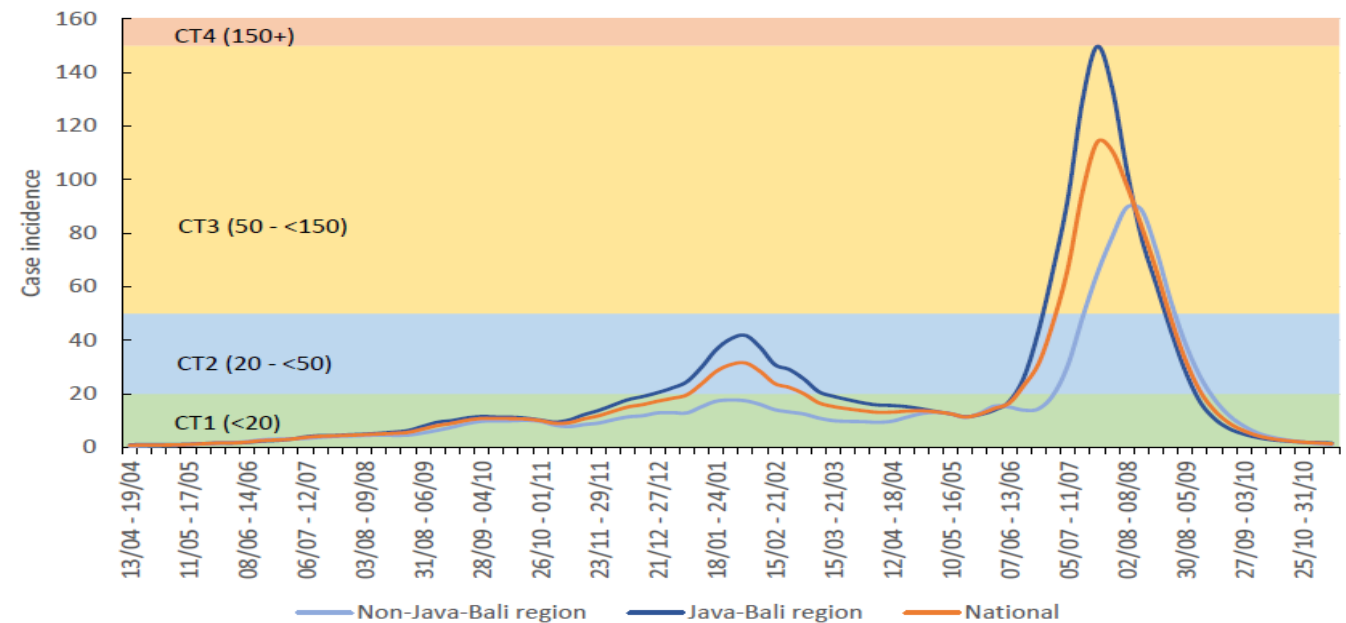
Incidence of COVID-19 per 100 000 population per week averaged over a two-week period reported at national and subnational levels (Java-Bali and non-Java-Bali) from 13 April 2020 (when Indonesia first reported community transmission in the country) to 14 November 2021, classified by level of community transmission (CT): CT1: low incidence; CT2: moderate incidence; CT3: high incidence; CT4: very high incidence. [Source of data](#)
